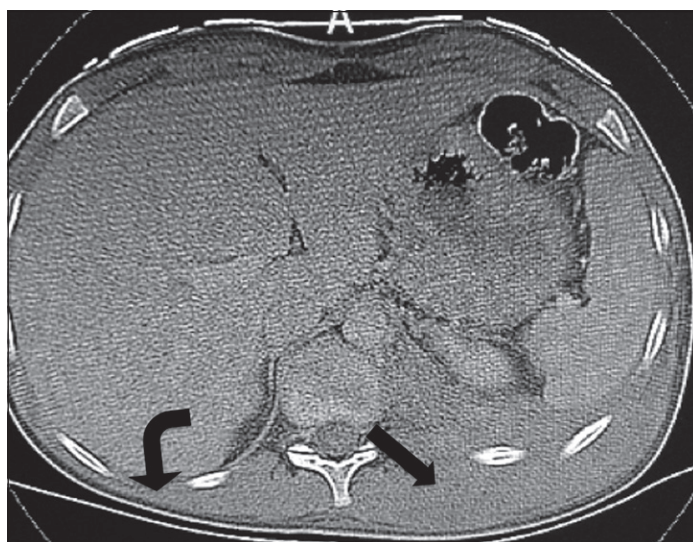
Computed tomography shows compromise of the left thoracolumbar wall, which is manifested as a significant increase in the volume of the soft tissues (arrow), the asymmetry is evident when compared with the right side (curved arrow)
